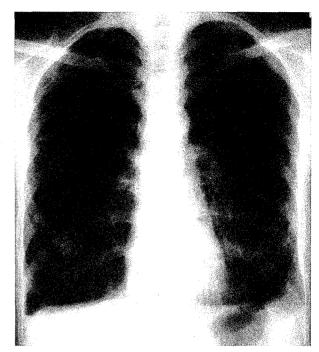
Chest radiograph (in 1999) shows more interstitial infiltration, honeycomb lesions, and hyperinflation compared to that of Figure 1 (in 1990); bilateral pleural thickness is also noted.
